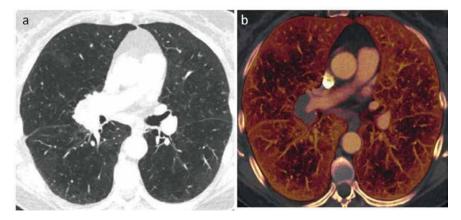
Seventy nine year-old female with a 50 pack-year history of smoking. Axial CT (a) and corresponding pulmonary blood volume image (b) at midlung level show decreased perfusion in areas of emphysema.
